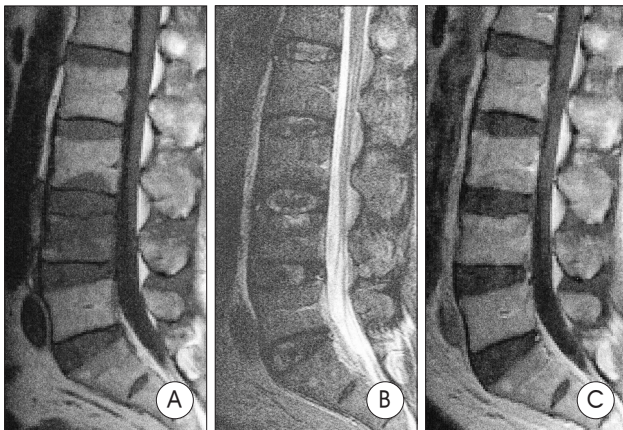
The initial magnetic resonance images of patient No. 1 at stage A2. The images show low signal intensity in both the endplates and the vertebral body on T1 WI (A) and slightly high signal intensity on T2 WI (B). No enhancement of the lesion is seen (C).
